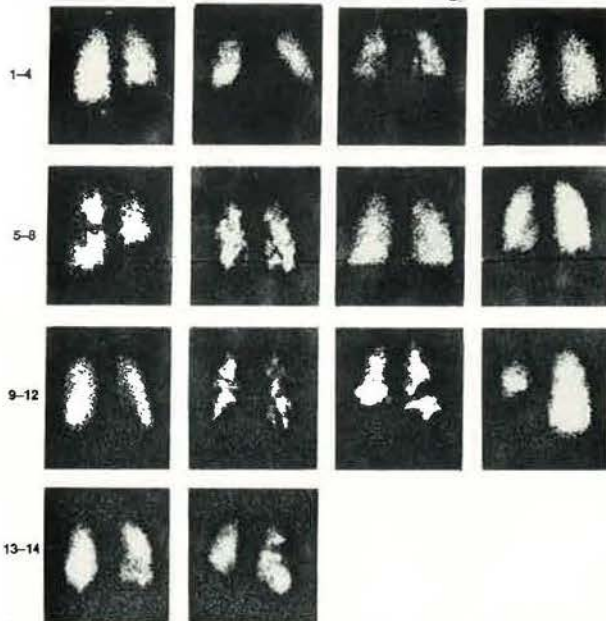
Ventilation scintigrams of the 14 (1-14) patients with primary ciliary dyskinesia.
